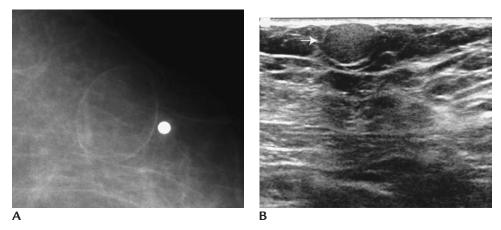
Oil cyst. (A) Oval mass, fat (lucent) containing with circumscribed margins corresponding to hard, palpable "lump" described by the patient (*metallic BB*). Fatty masses are benign lesions. (B) Oval iso- to slightly hyperechoic mass (*arrow*) corresponding to palpable finding. The benign diagnosis is established mammographically and, although the ultrasound is included out of interest, it is not indicated.
